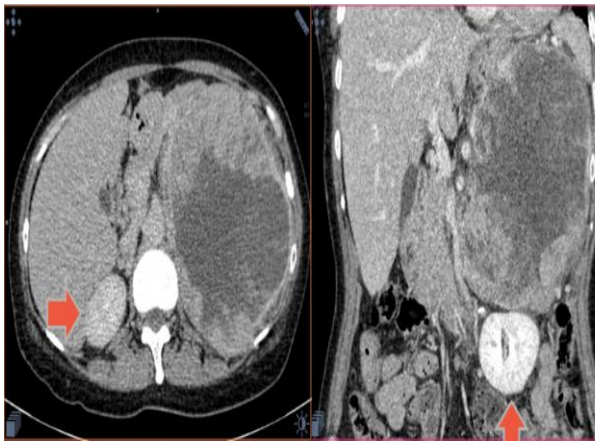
CT urogram: Large, heterogeneously enhancing necrotic mass in the left suprarenal region with vascularities at the periphery. The mass displaces the left kidney inferiorly, the stomach medially, and the pancreatic body and tail superiorly. The left renal hilar vessels were also displaced posteromedially.
